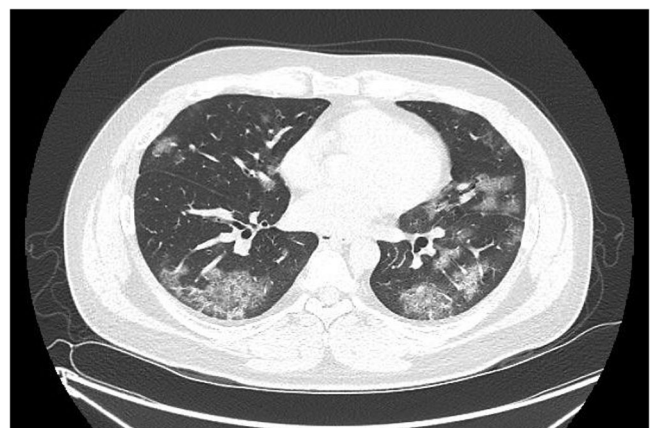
Thoracic computed tomography image on admission
